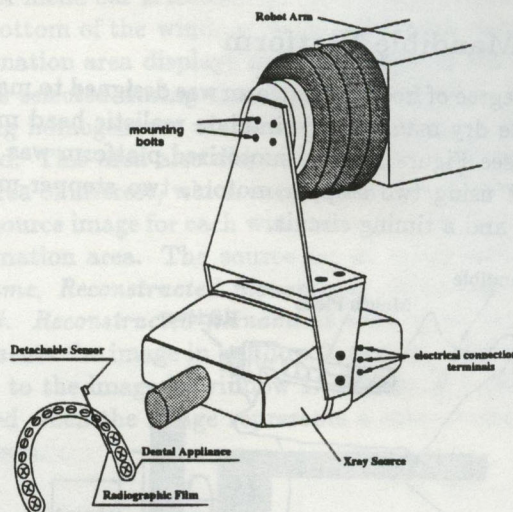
Mounting of X-ray Device
